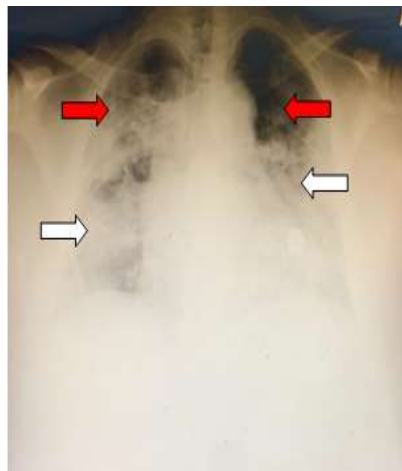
Chest X-ray of a 56-year-old male patient with positive RT-PCR for Covid-19 and had received a vaccine injection 5 months earlier. Four days later the patient died.
